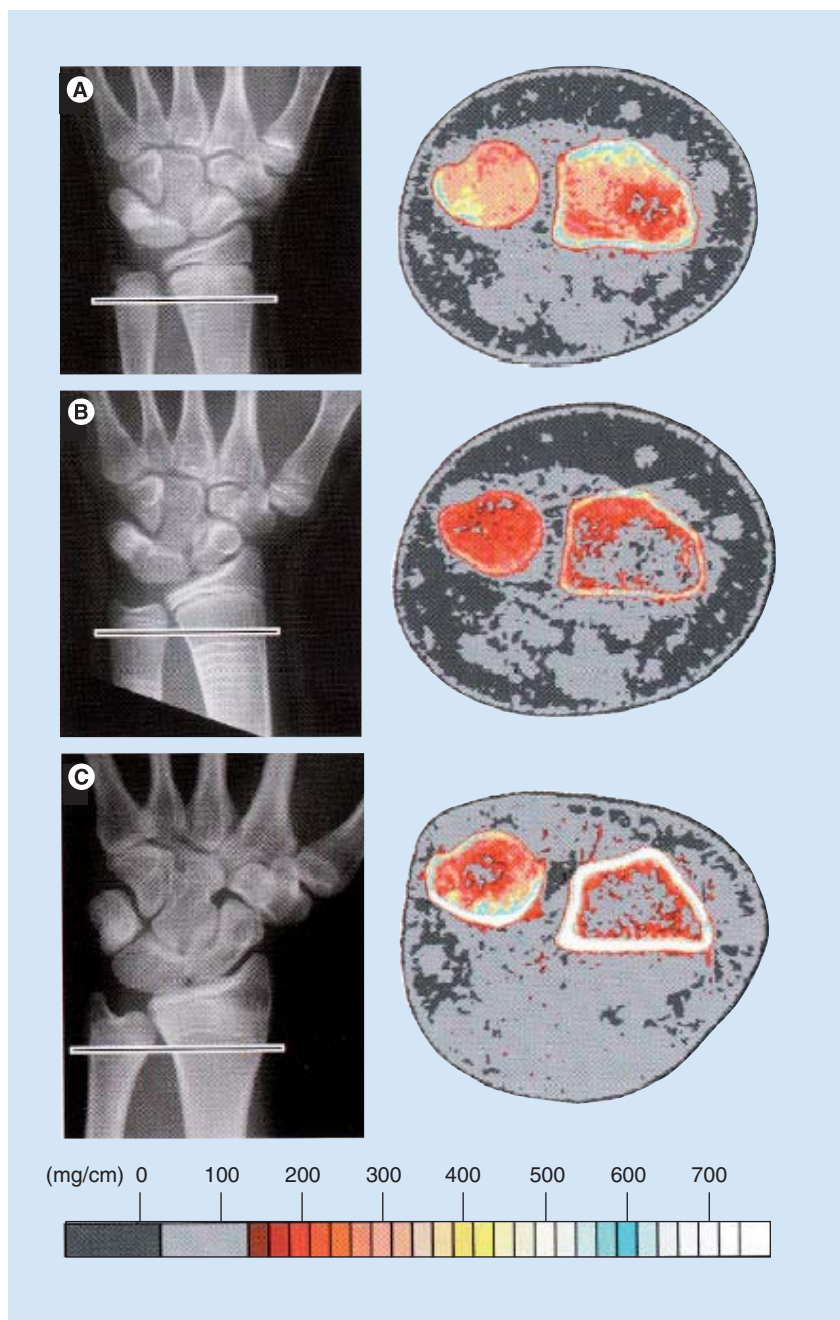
Radiographs of the distal forearm and wrist and corresponding pQCT images. The bar in the radiograph indicates the approximate site of the pQCT analysis. (A) Findings at the time of pamidronate discontinuation in a 12-year-old girl with osteogenesis imperfecta type IV. The patient received pamidronate cycles every 4 months for 6 years. Each treatment cycle led to the formation of a transverse line in the metaphysis. The BMC Z-score of the radius (the bone on the right side of the cross-sectional image) is +2.7. (B) Same patient as in (A) at 18 months following pamidronate discontinuation. Growth proceeded after treatment discontinuation. The pQCT section now presents bone that formed after the last cycle of pamidronate. The BMC Z-score is -2.7. (C) Man with osteogenesis imperfecta type 1 at 20 years of age, 2.2 years after pamidronate discontinuation. Pamidronate was started at the age of 14 years. The distal radius growth plate fused soon thereafter. Therefore, the metaphyseal lines do not reach the site of the pQCT analysis. Consequently, the BMC Z-score remained negative (-1.1) at the end of the pamidronate treatment. BMC: Bone mineral content; pQCT: Peripheral quantitative computed tomography. Adapted with permission from [24].
